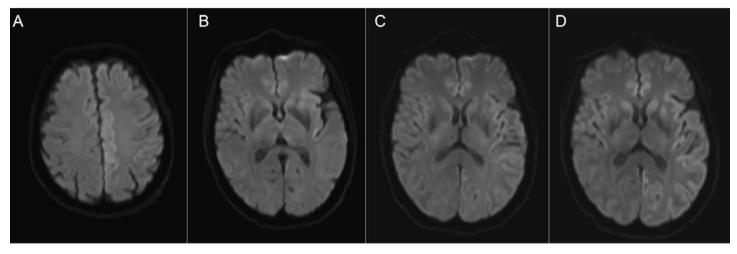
Progressive cortical ribboning: Parasagittal(A) and mild left insular(B) cortical ribboning on hospital day 2. Enlarged left hemisphere and mild right temporal-parietal involvement are shown on hospital day 21(C). Caudate DWI hyperintensities and more prominent right hemisphere cortical ribboning are noted on hospital day 32.
